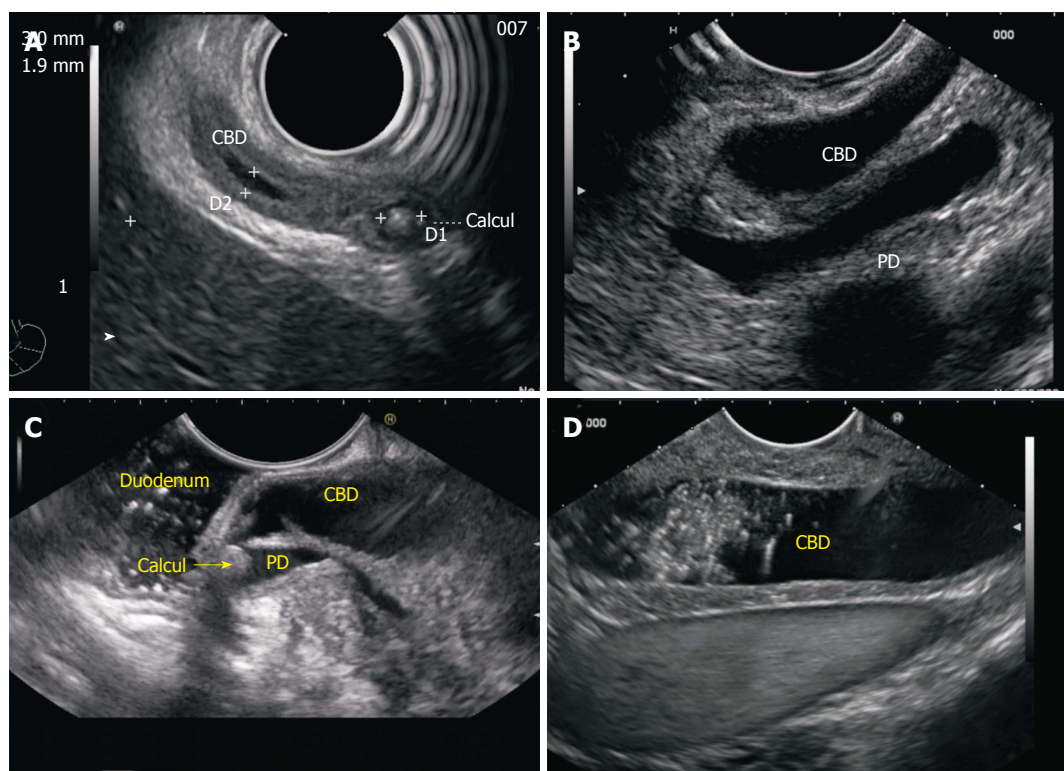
Imaging from 2nd part of duodenum. A: The intrapapillary part of CBD and the lower 1/3 of CBD is sometimes best visualized with the radial EUS scope as they provide a long axis of imaging of the entire bile duct in a long axis; B: However good view of CBD in a long axis can be also obtained by linear EUS scope. This image shows the dilated CBD and PD in a long axis in a case of periampullary carcinoma; C: The distended CBD may not provide room for good visualization as it comes very close to probe in a pathology involving papilla. This figure shows good view of CBD after instillation of 100 mL water which provides good coupling and also provides adequate focal distance. The stone is impacted in the common channel where it is also obstructing and dilating the pancreatic duct; D: The dilated CBD with sludge is seen from 2nd part of duodenum. On the far side of screen the IVC is also seen beyond the IVC. CHD: Common hepatic duct; EUS: Endoscopic ultrasound; IVC: Inferior venacava; CBD: Common bile duct; PD: Pancreatic duct.
